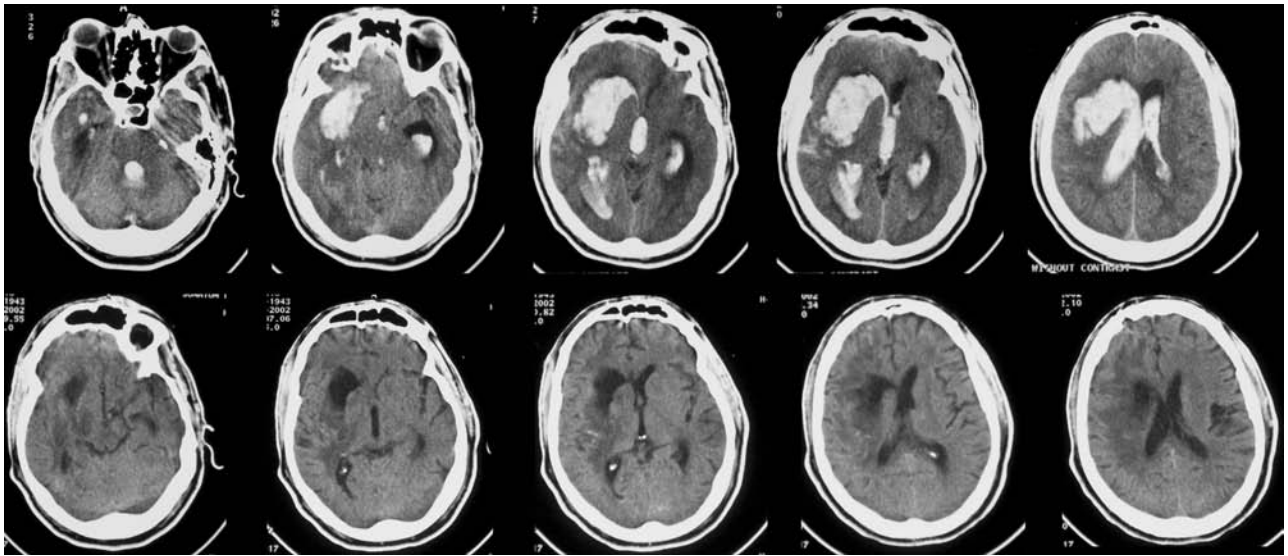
(Top) Admission head CT scan in patient 8 demonstrating a right basal ganglia ICH with IVH involving the entire ventricular system. (Bottom) Head CT scan 14 days later after clot aspiration and lysis with rtPA. Note the complete resolution of the ICH and IVH. No intraventricular thrombolysis was administered in any of the 15 patients reported here.
